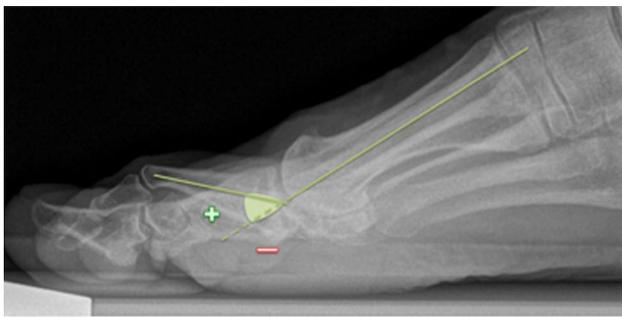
Lateral X-ray showing the metatarsophalangeal joint angle, defined as the angle between proximal phalanx and metatarsal. Positive is defined when the joint is in extension with respect to the diaphysis line of proximal bone. Negative is defined when the joints are in flexion with respect to the diaphysis line of proximal bone
